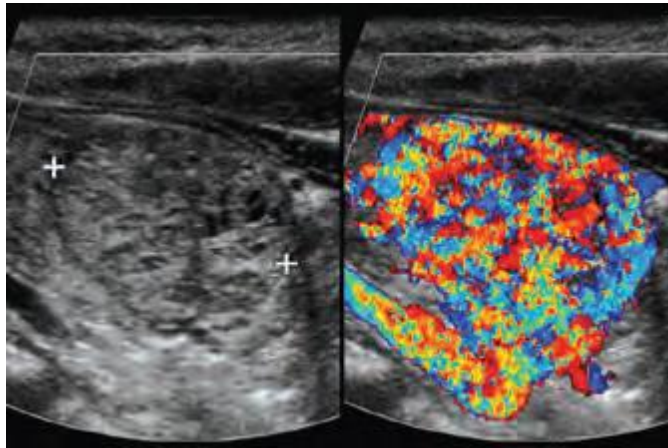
Dual gray-scale and color Doppler views show a hypervascular
